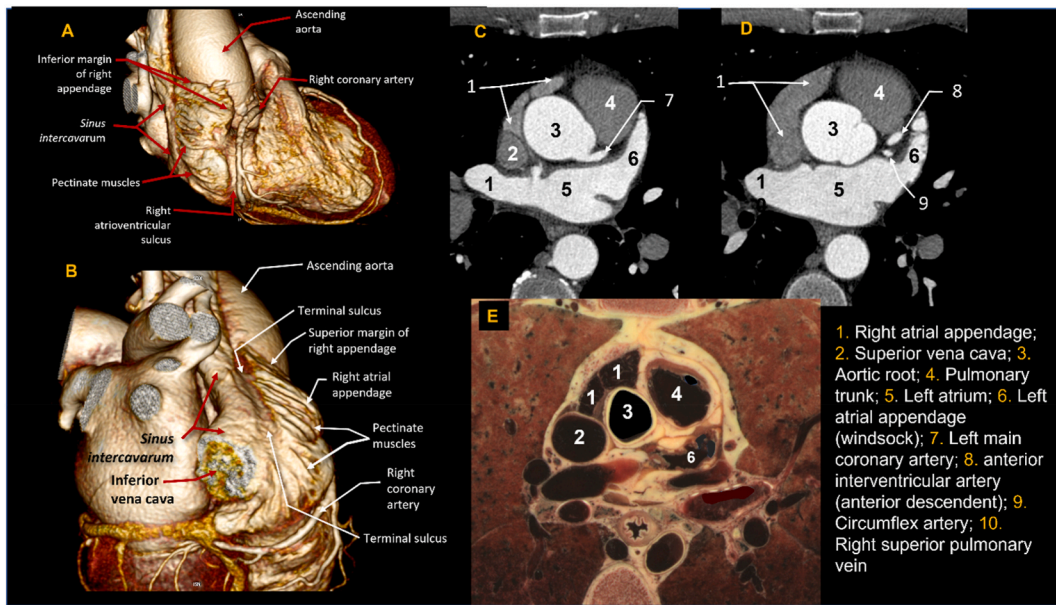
(A–E). Volume rendering (A,B) and Axial reconstruction (C,D) CT images highlighting right and LAA main features and its anatomical landmarks. Axial section through human thorax showing LAA and RAA (E; courtesy of Prof. R.D. Hersch. École Polytechnique Federale de Lousanne (EPFL), Switzerland. Visible Human Web Server. <http://visiblehuman.epfl.ch>).
